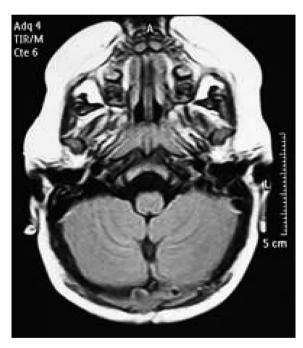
Axial T1-weighted MR image in the early postoperative period revealing total removal of the cyst.
